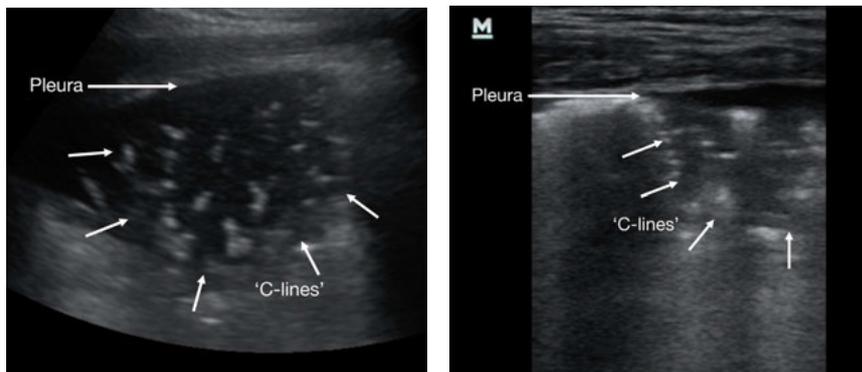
Convex (L) and linear (R) ultrasound scans demonstrating tissue-like structure in the lungs. Consolidations (sometimes called 'C-lines') may contain visibly echogenic, string-like air-bronchograms.
